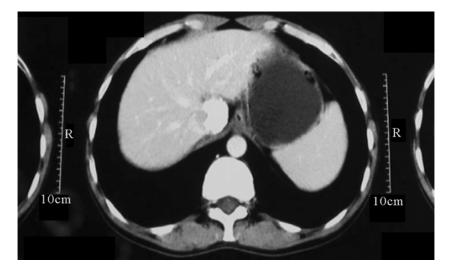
CT showing a tumor in the caudate lobe
